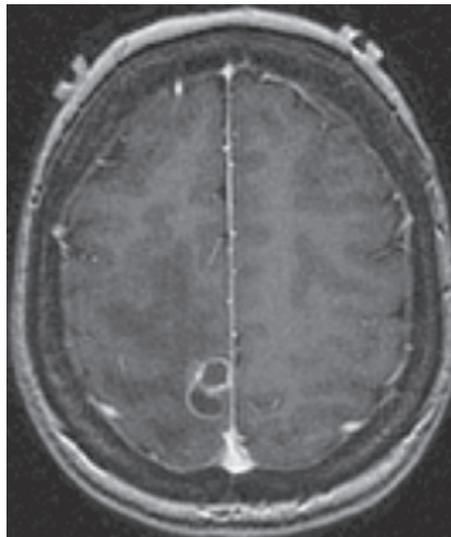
Brain abscess. Magnetic resonance imaging with gadolinium shows a multiloculated ring-enhancing lesion caused by *Nocardia* species infection.
